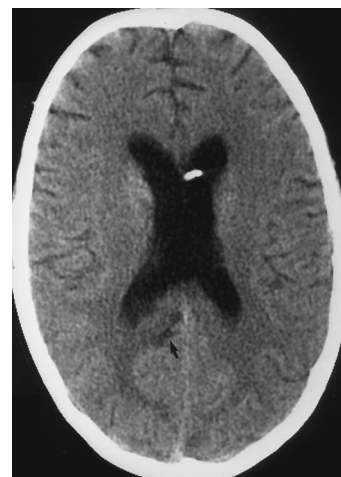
Unenhanced axial CT scans of the head. A, an EVD in place in the right frontal horn. B, CT scan performed 24 hours after the initial dose of rtPA was administered. C, CT scan after the fourth dose of intraventricular rtPA. There is complete clearing of blood from the frontal horns, with residual blood in the right temporal horn.
